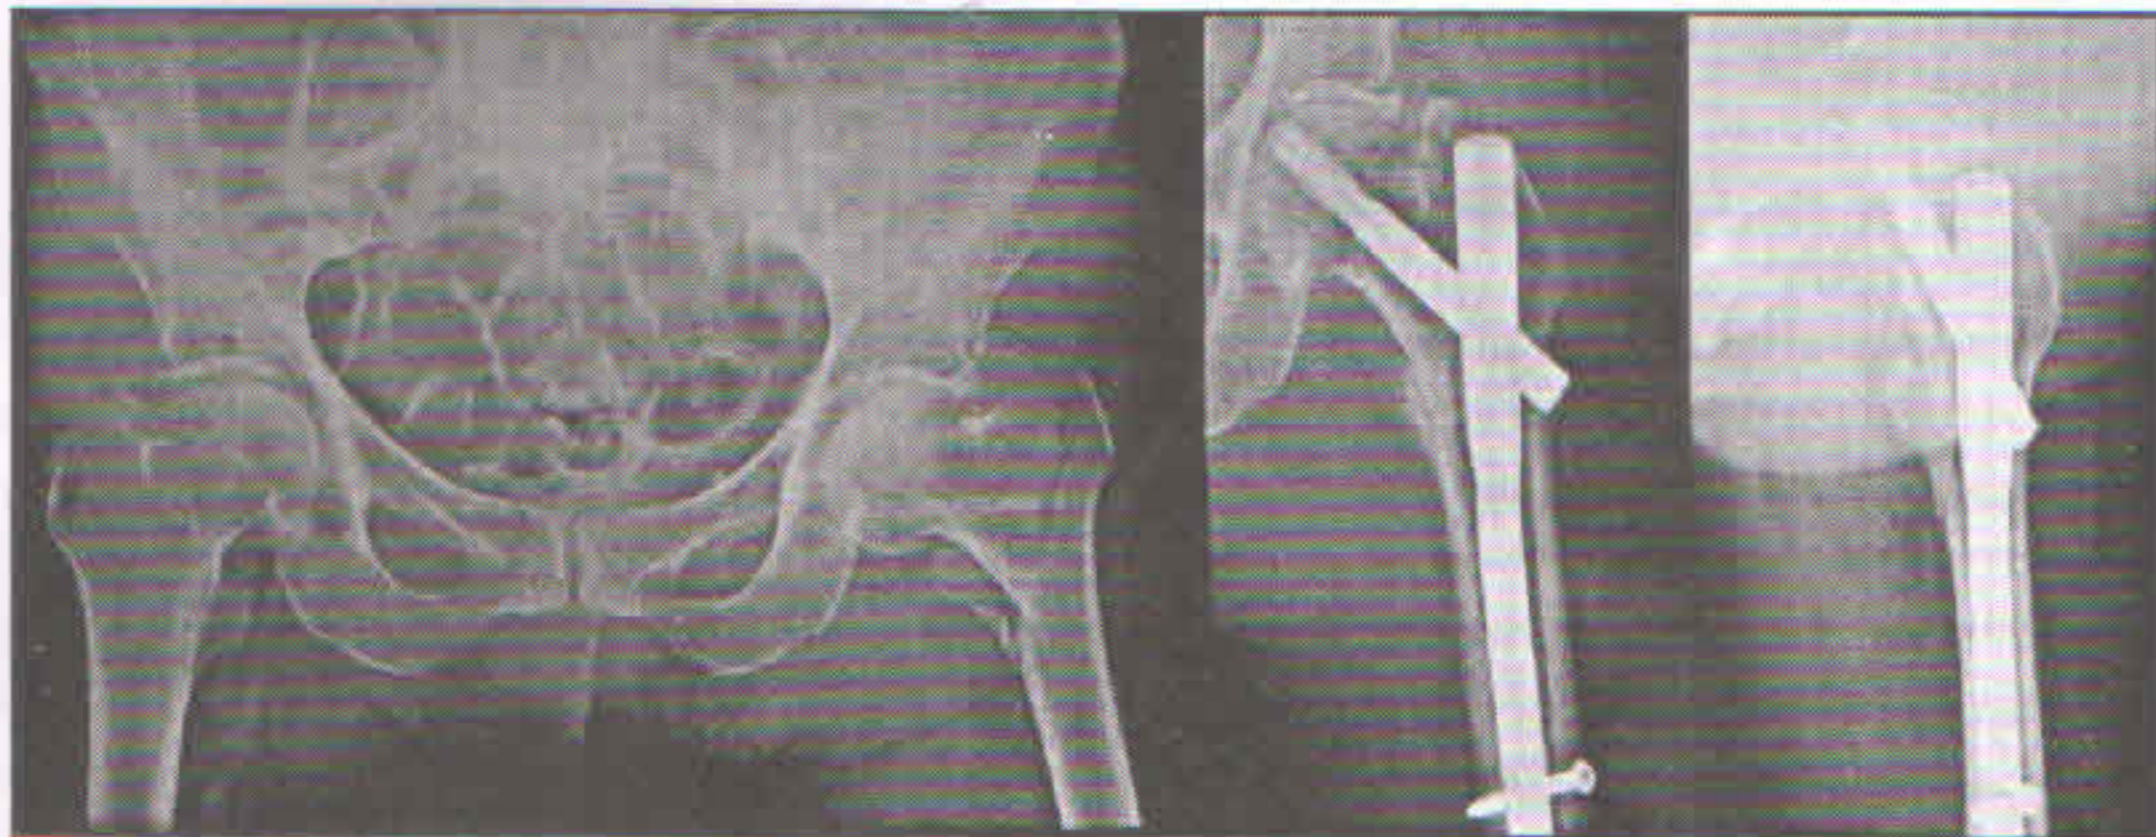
Preoperative radiographs 78 years old female with AO -31 A2. 2 (left). Six months follow up showing fracture healing despite slightly longer blade positioning than ideal no perforation into the hip occurred.
